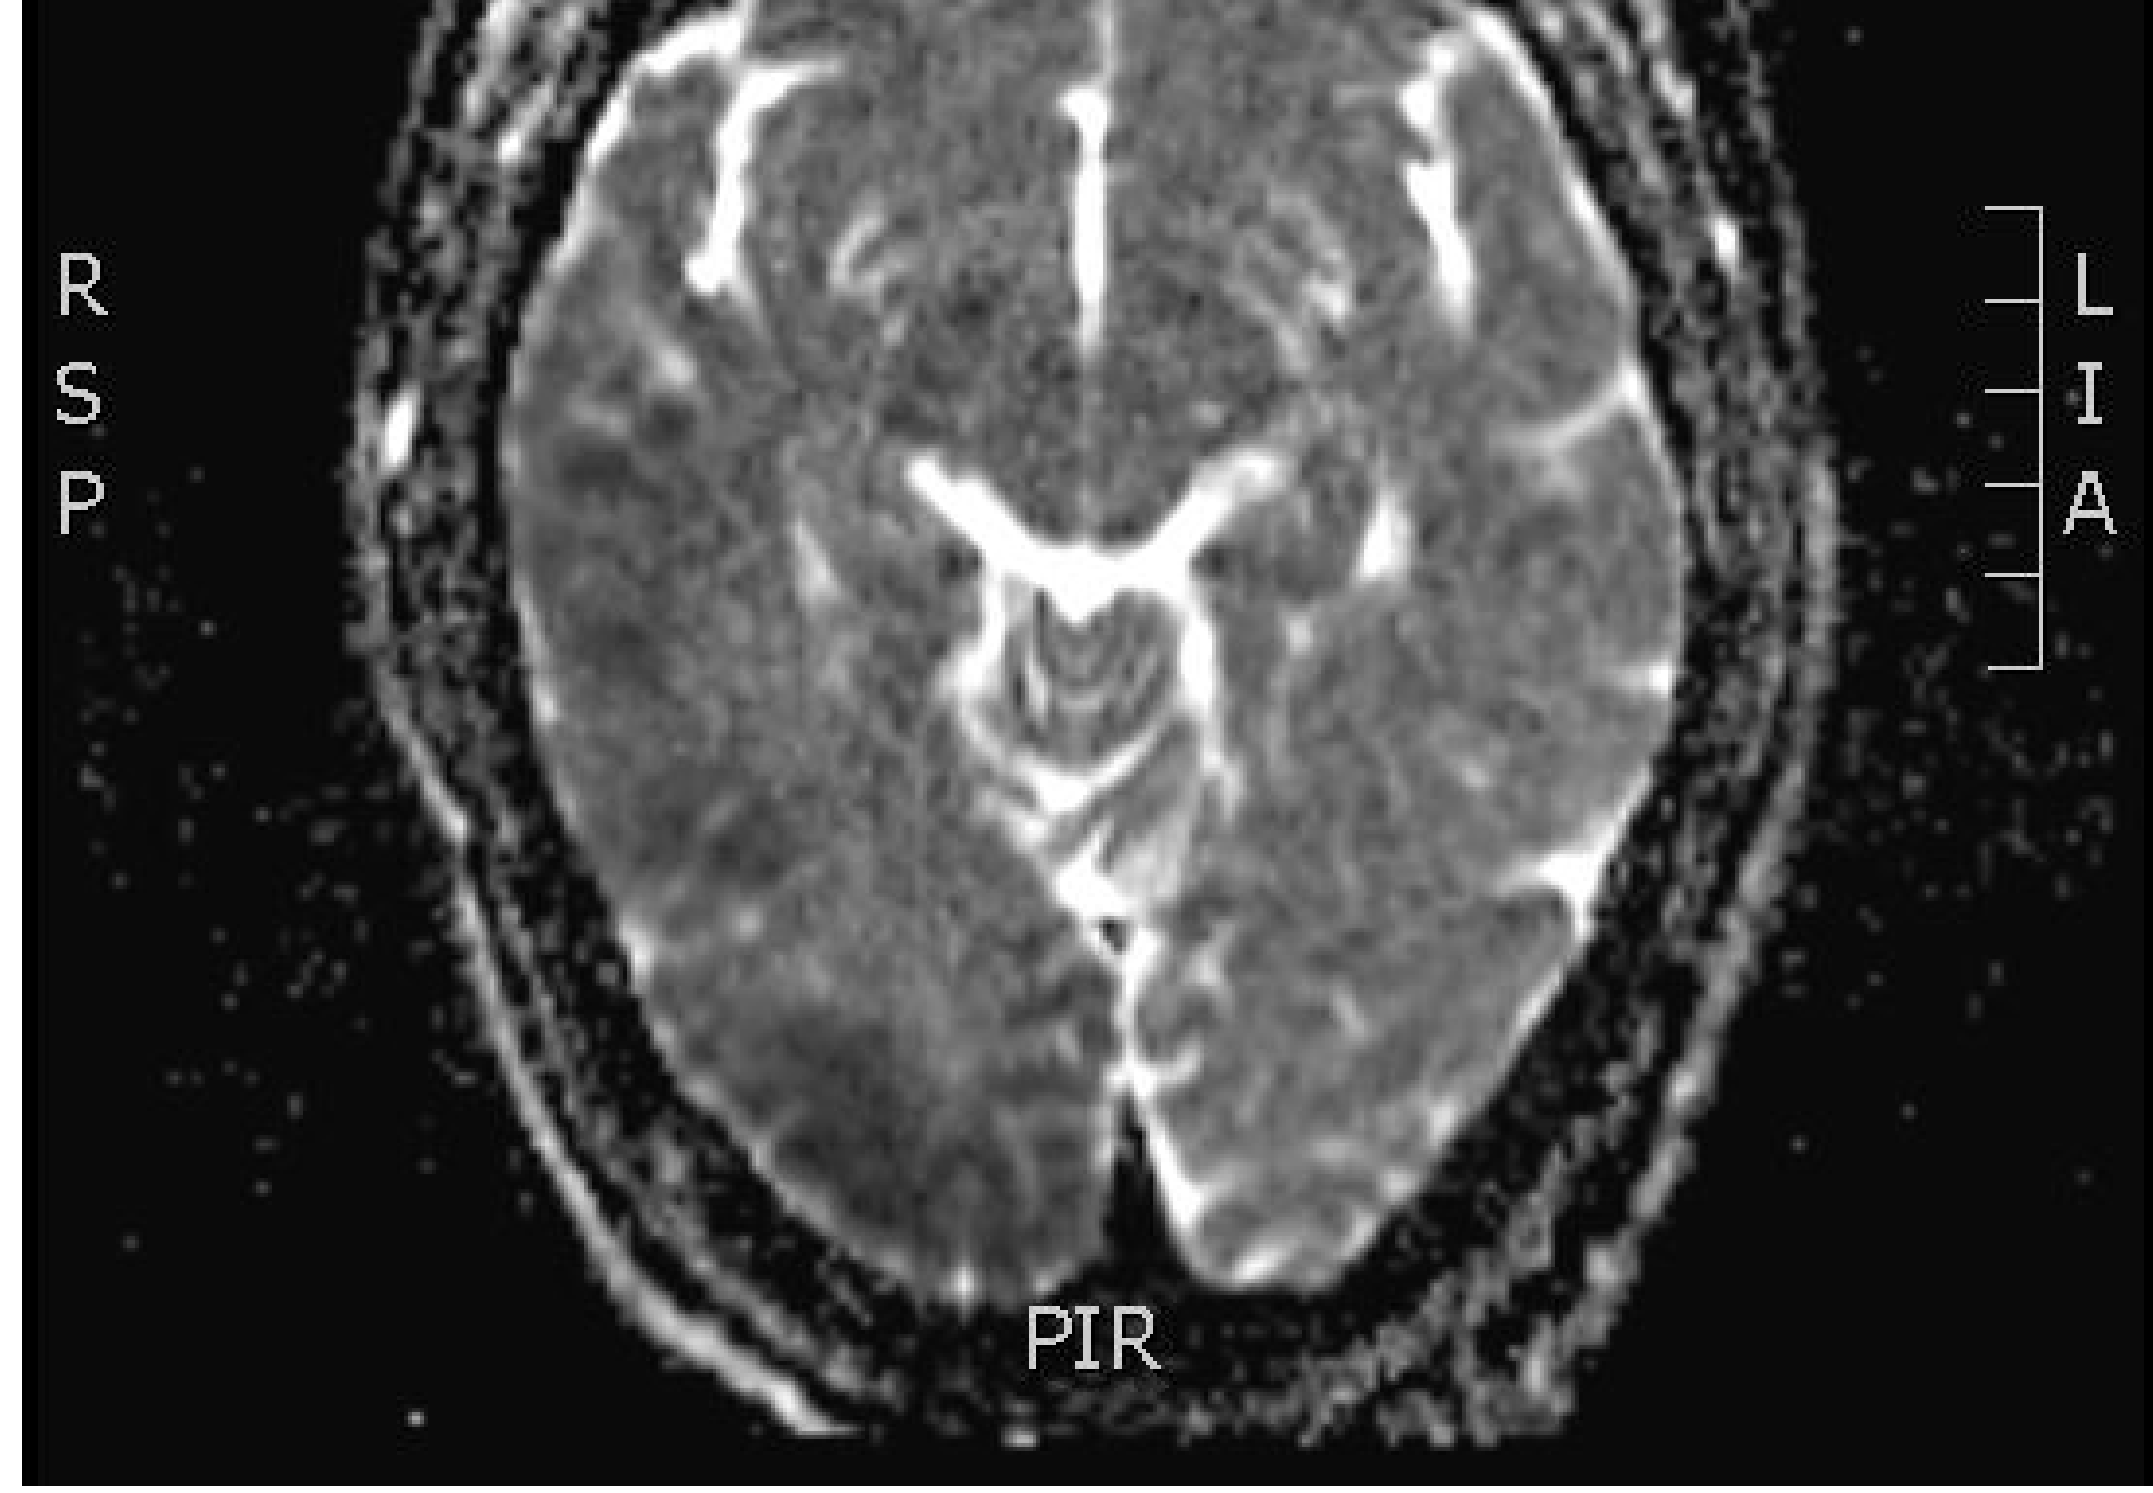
MRI depicting right cerebral hemisphere stroke
